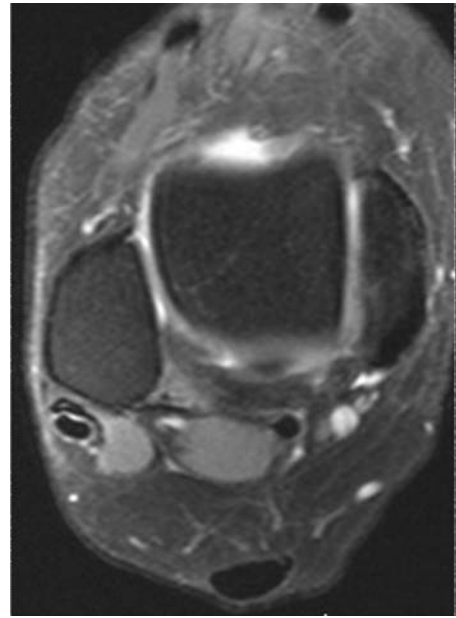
Note the increased intensity in the T2-weighted image.
